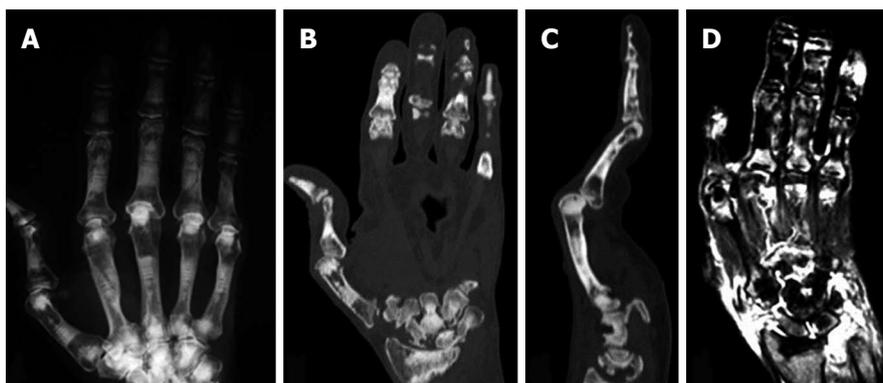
Plain X ray (A), computed tomography scan (B and C) and magnetic resonance imaging (D) of the right hand of an autosomal dominant II patient with rheumatoid arthritis. Erosion of the carpal bones (B) and severe synovitis, as determined by the high intensity areas by T2-weighted magnetic resonance imaging images (D), were observed^[14].
